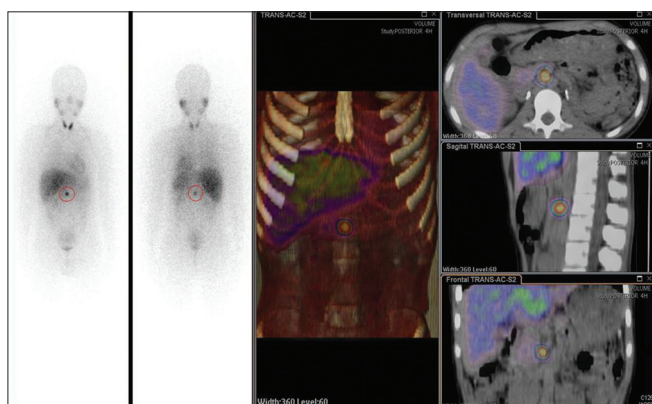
Planar and SPECT/computed tomography images which demonstrates the focal uptake was a node located between superior mesenteric artery and the uncinate process of the pancreas, above the aorta
